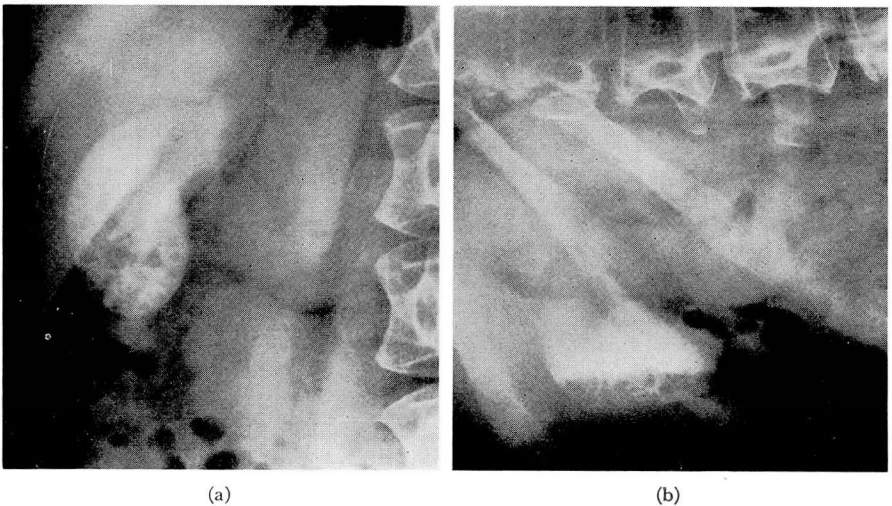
Cholelithiasis. (a) Posteroanterior prone roentgenogram showing multiple nonopaque calculi. (b) Posteroanterior lateral decubitus roentgenogram where calculi have settled to bottom of the gallbladder silhouette. Note increased contrast between calculi and dye-containing bile above.
